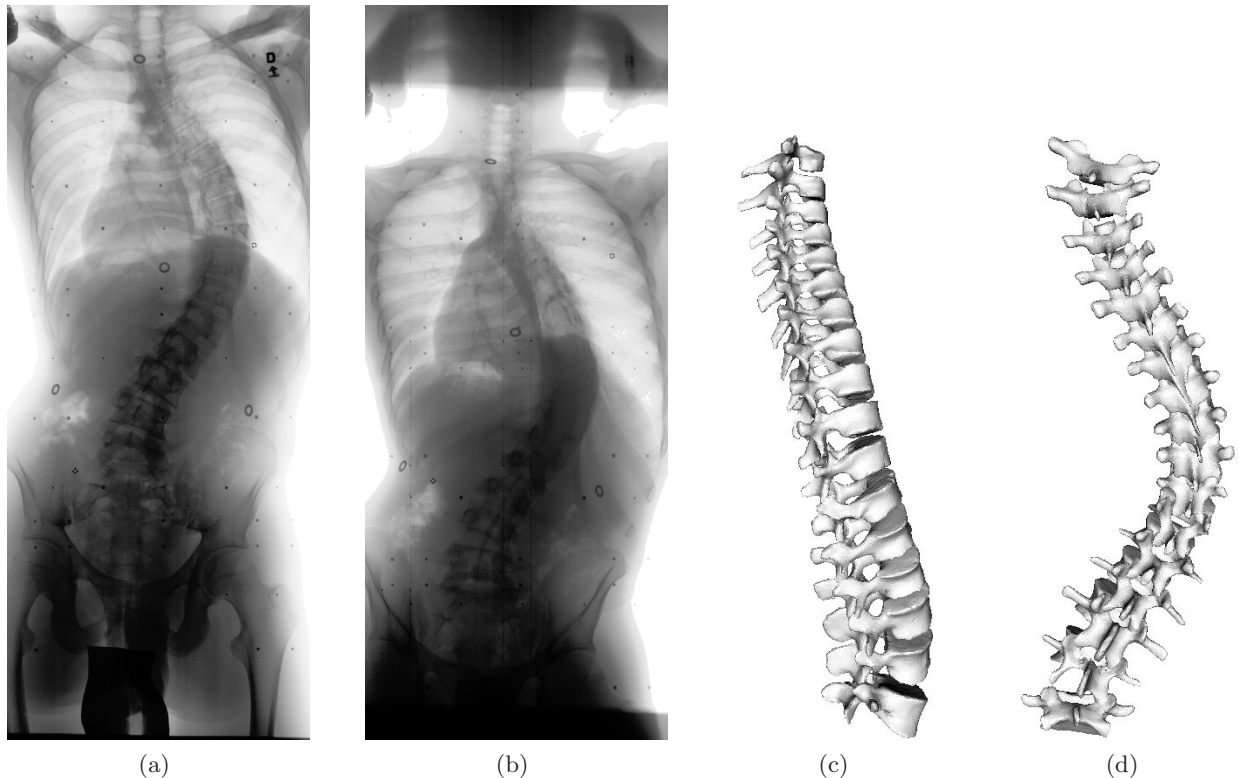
Example of a reconstruction of a 3D spine model from two radiographs. (a) Posterior-anterior radiograph. (b) Posterior-anterior radiograph angled down by 20 degrees. (c) Lateral view of the reconstructed 3D spine model. (d) Posterior view of the reconstructed 3D spine model.
